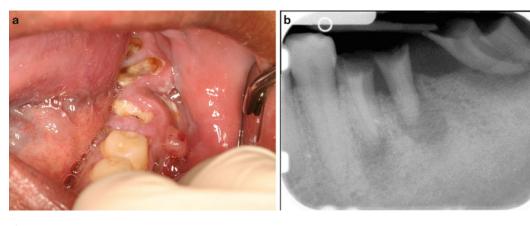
Left mandibular gingival swelling due to a draining abscess (a) associated with the remaining decayed and broken down molar roots. (b) Periapical
